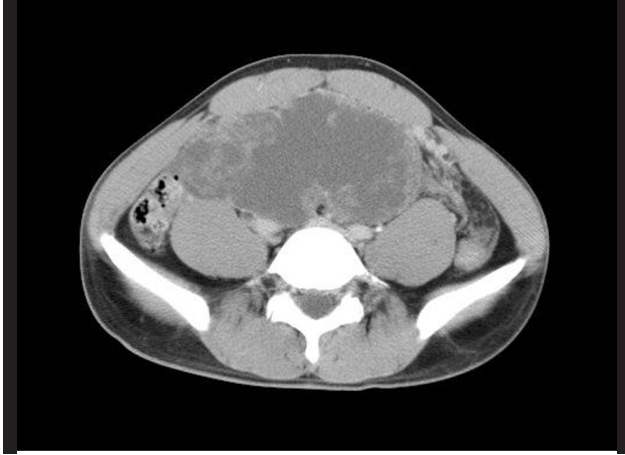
The axial computed tomographic (CT) scan shows a large, well demarcated, lobulated, soft tissue mass filling up the pelvic cavity. The low density within the mass is noted.
